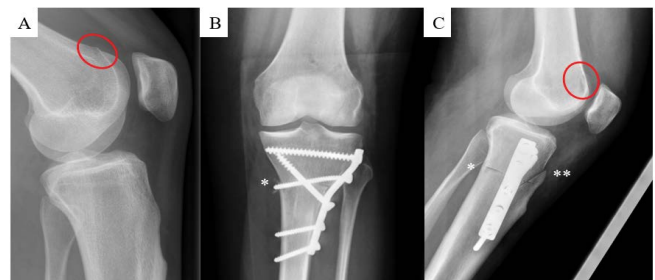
(A) Dysplasia of the trochlea is shown by lateral radiograph of the knee and femoral “bump” is marked (red circle). Postoperative X-ray documents main osteotomy level (*) and vertical cut superior to tibial tubercle () on ap- view (B) and lateral view (C). Fixation is achieved by an individually bended 5-whole DC-Plate with the typical pattern of screws.
